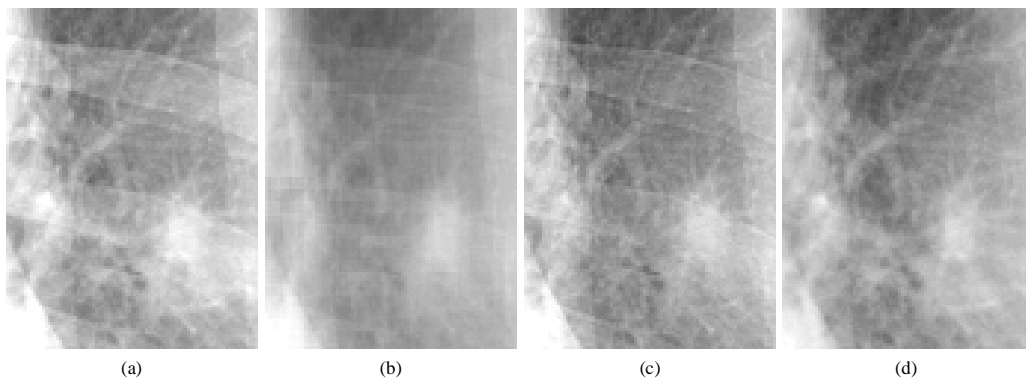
Enlarged images of ROIs of a nodule in (a) original chest radiograph, (b) “soft-tissue-image-like” image obtained by use of the MTANN, (c) bone-subtracted image obtained by use of our scheme, and (d) “ideal” soft-tissue image obtained by use of the dual-energy subtraction technique.
